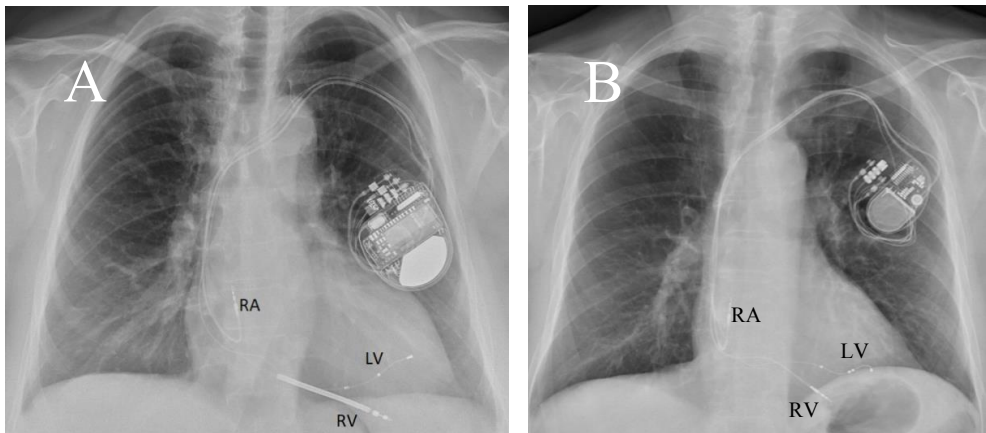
Chest X-rays in posteroanterior view. A) A CRT-D device with a lead in the right atrium (RA), an ICD lead in right ventricle (RV) and an active fixation left ventricular lead in a lateral branch from coronary sinus (LV). B) CRT-P device with a conventional pacing lead in the right ventricle (RV) and a quadripolar passive fixation left ventricle lead in a posterolateral branch from coronary sinus.
